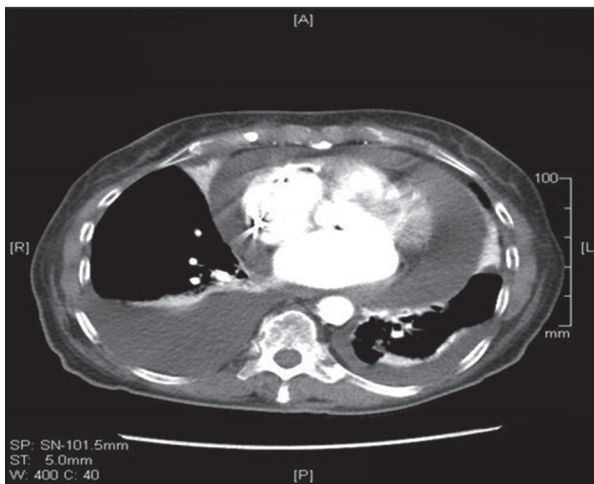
CT scan of patient 2 showed pericardial and pleural effusion four weeks after pacemaker implantation.
